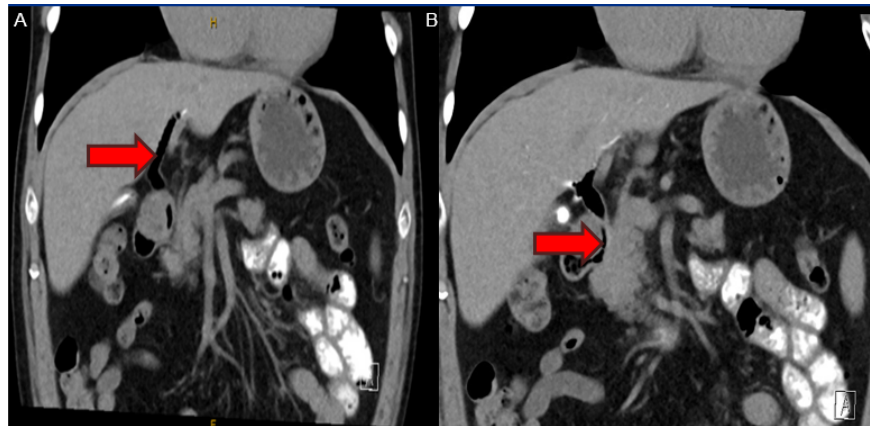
(A) CT abdomen and pelvis coronal section demonstrating the presence of pneumobilia, as indicated by the red arrow; (B) CT coronal section demonstrating the presence of a subtle yet possible tissue bridge between the common bile duct and duodenum, suspicious for a CDF, as indicated by the red arrow.
